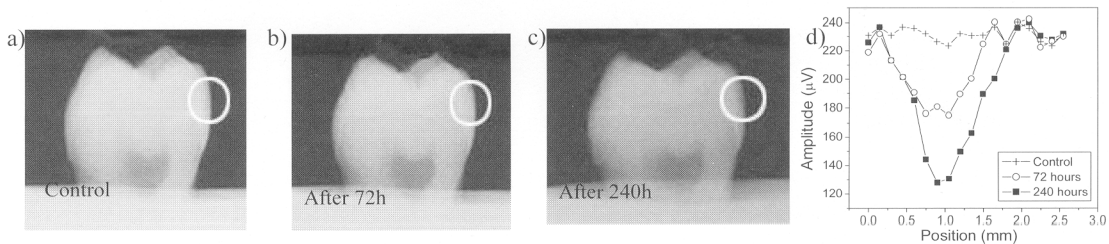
Radiographs and experimental results of sample C1. (a) Sample C1 prior to etching. (b) Sample C1 after 72h of etching. (c) Sample C1 after 240h of etching and starting to show evidence of enamel demineralization. (d) PTR amplitude across the scanned line at 30Hz.
